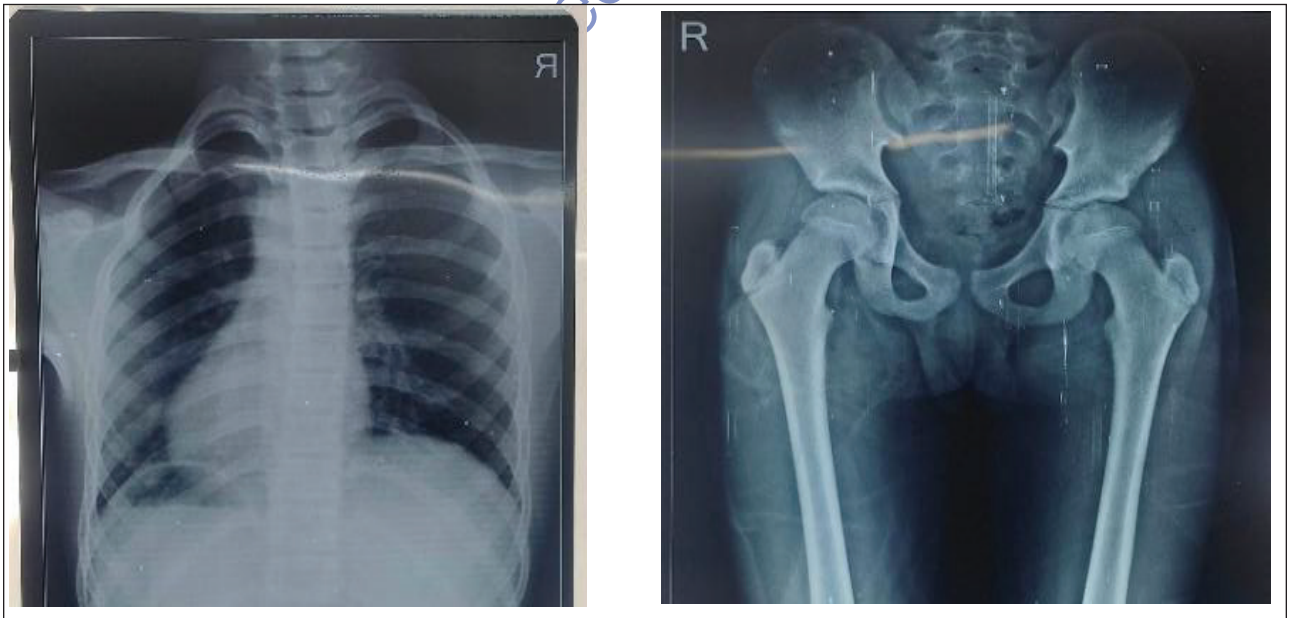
Plain chest and pelvic x-ray.
